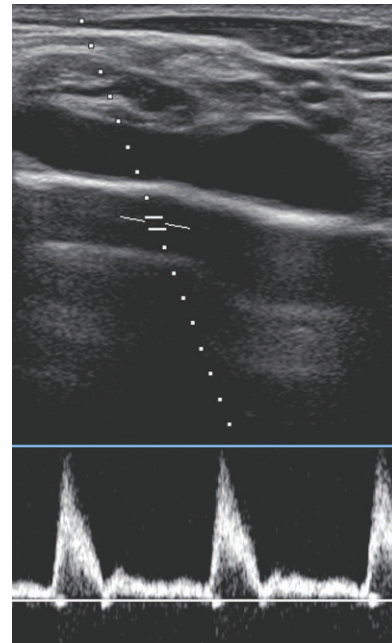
A mirror image subclavian artery spectral Doppler is present below the true artery. The presence of a spectral signal does NOT exclude a mirror image. Anatomically there is not a second artery below and parallel to the subclavian artery.
